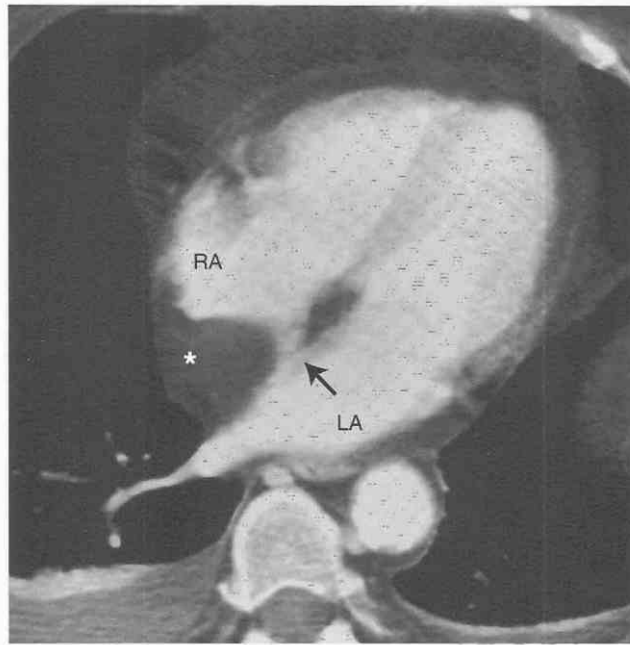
Lipomatous hypertrophy of the interatrial septum. Axial CT with intravenous contrast medium shows increased fat deposition within the interatrial septum (*asterisk*). A characteristic bilobed shape is caused by sparing of the fossa ovalis (*arrow*). LA, left atrium; RA, right atrium.
